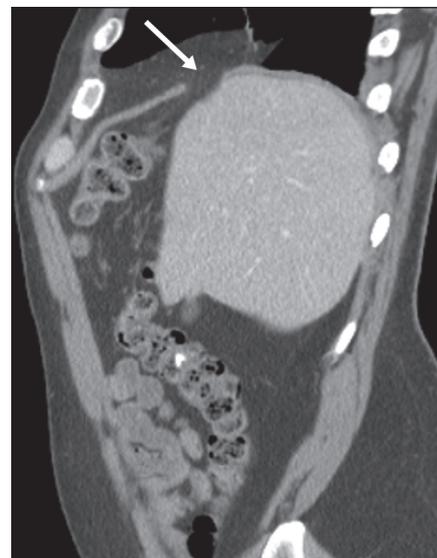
Right diaphragmatic tear. Sagittal reformation of CT image obtained in patient who suffered blunt abdominal trauma shows focal defect in dome of right hemidiaphragm (*arrow*), with associated herniation of intraperitoneal fat into right hemithorax.
